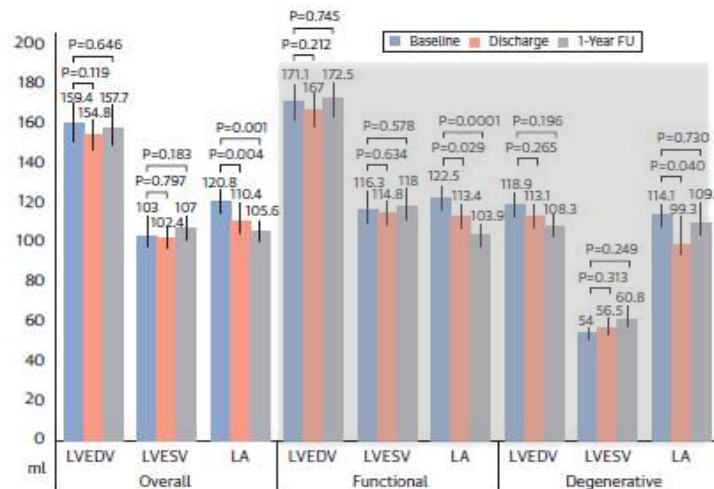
Echocardiographic Measurement of Left Ventricular and Left Atrial Volumes at Baseline, Discharge, and 1-Year Follow-Up After TMVR (Paired Data From 368 Patients)
